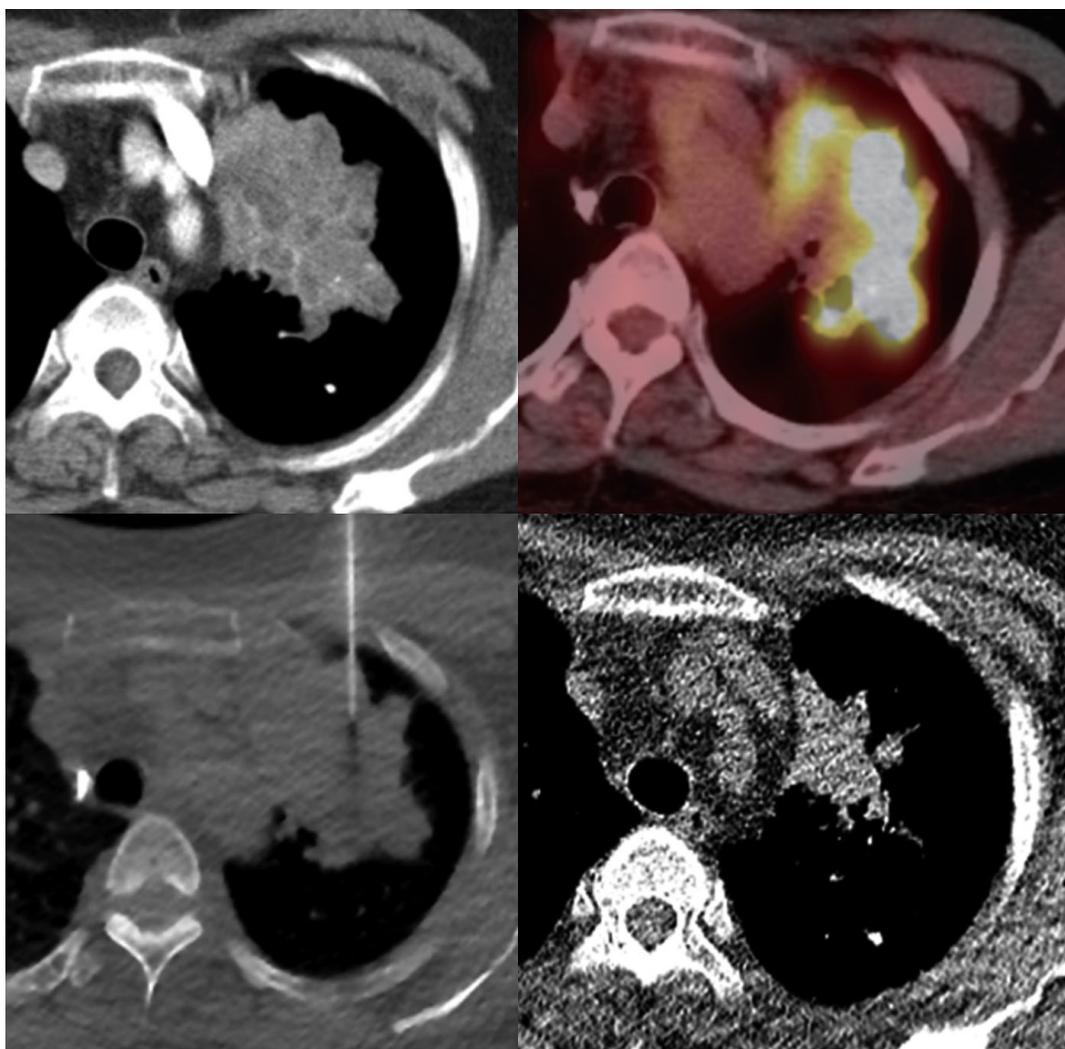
A 61-year-old female with a heterogeneous, lobulated mass with suspicious necrosis, located at the left upper lobe. PET/CT scan demonstrates high metabolic uptake at the peripheral area of the lesion (SUVmax of 16.7). Thus, the biopsy needle tip is placed at the lesion with highest metabolic uptake. Pathologic results revealed pulmonary tuberculosis. Low-dose chest CT scan (right lower quadrant) after 6 months of anti-tuberculous treatment shows interval decrease of the lesion.
